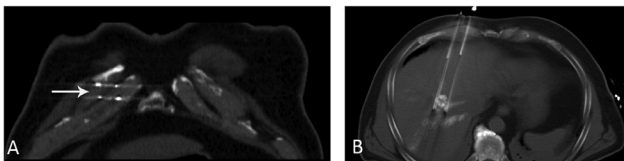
(A) Intraprocedural coronal computed tomography demonstrates placement of 2 irreversible electroporation probes through the interchondral space along the inferolateral and superomedial aspect of the tumor. The final 2 probes were advanced through the costal cartilage facilitated by the bonopty sheath in the inferomedial and superolateral aspect of the tumor. The white arrow denotes the probe array.
